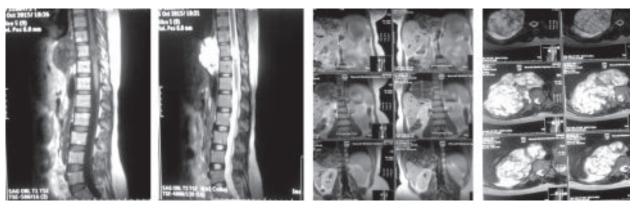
MRI showing extensive Chondrosarcoma of the dorsal spine.
